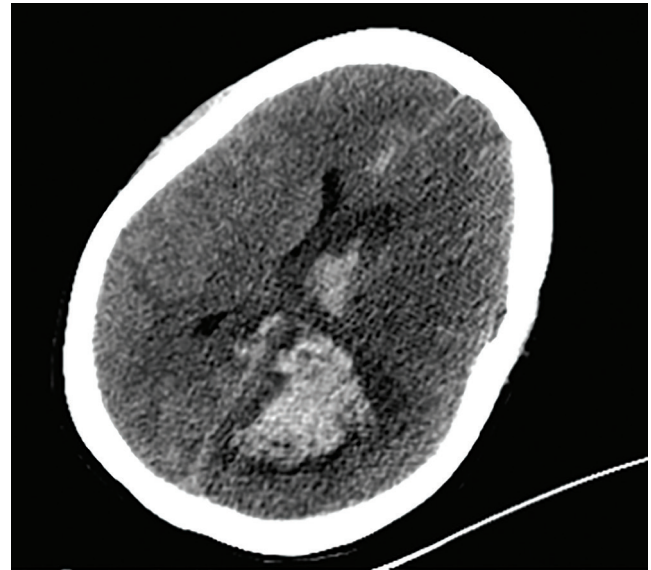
Preoperative cerebral CT scan showing a large hemorrhagic area in the left parieto-occipital region extending into the ventricles
